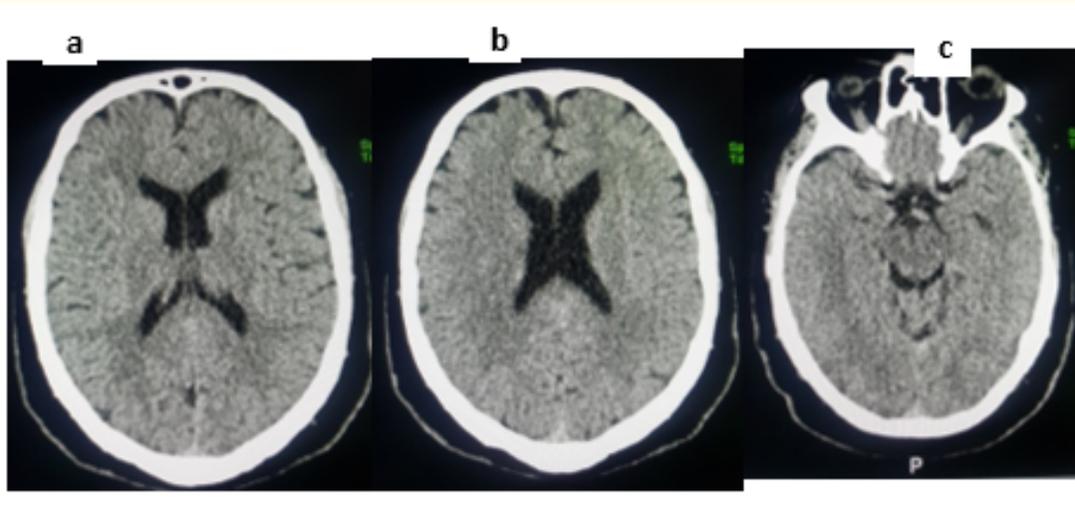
CT brain (axial) show no indirect sign of ischemia, no hemorrhage and no midline shift.
